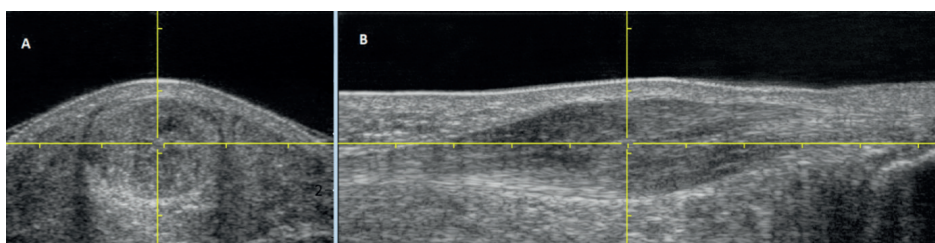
Achilles tendon thickness measurements with conventional ultrasound of the insertion (A) and midportion (B) of the tendon. The largest AP diameter of the Achilles tendon perpendicular to the latero-medial width was measured in the transversal view.<sup>9</sup> This section of maximum thickness was frozen and subsequently the thickness was measured directly (yellow dotted line).
